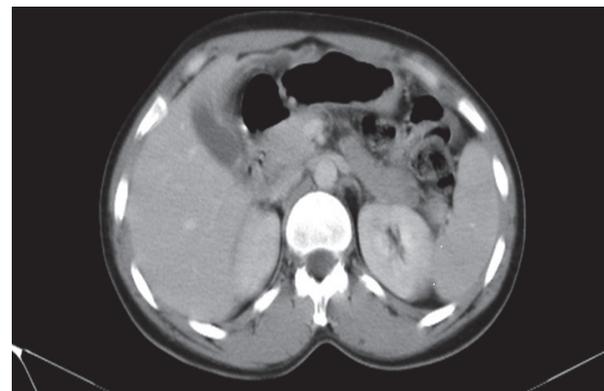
Axial CT images, obtained 2 weeks later from first admission, revealed the disappearance of cystic liver mass with minimal free fluid at the location of previous lesion.
